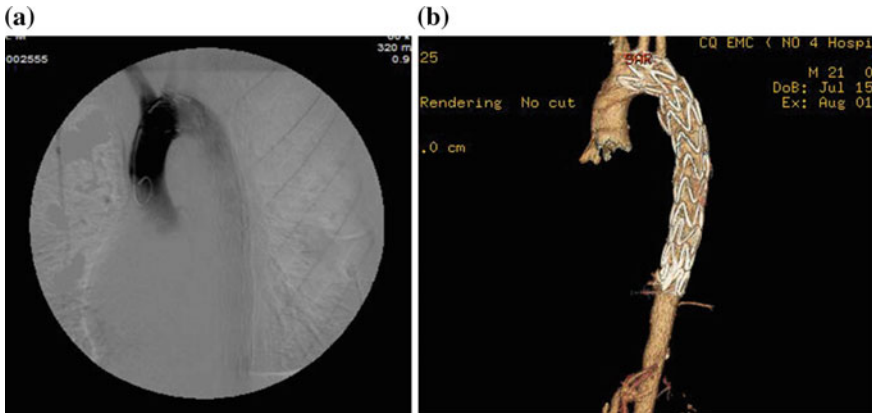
The same trauma patient showed in Fig. 4. Repeated examination by DSA and CTA after thoracic endovascular repair
